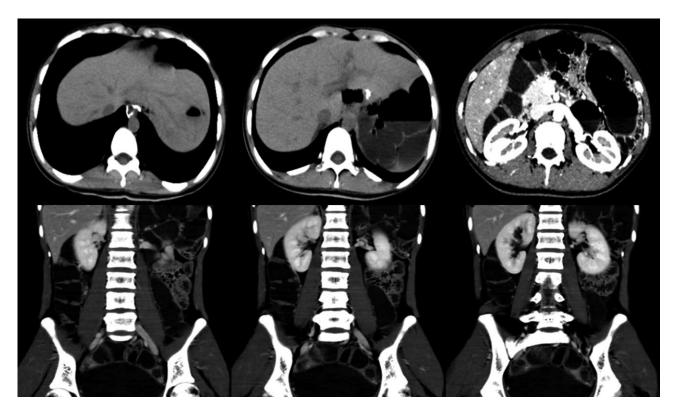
Follow-up abdominal computed tomography scan after 10 mo showing no signs of recurrence and metastatic disease.
